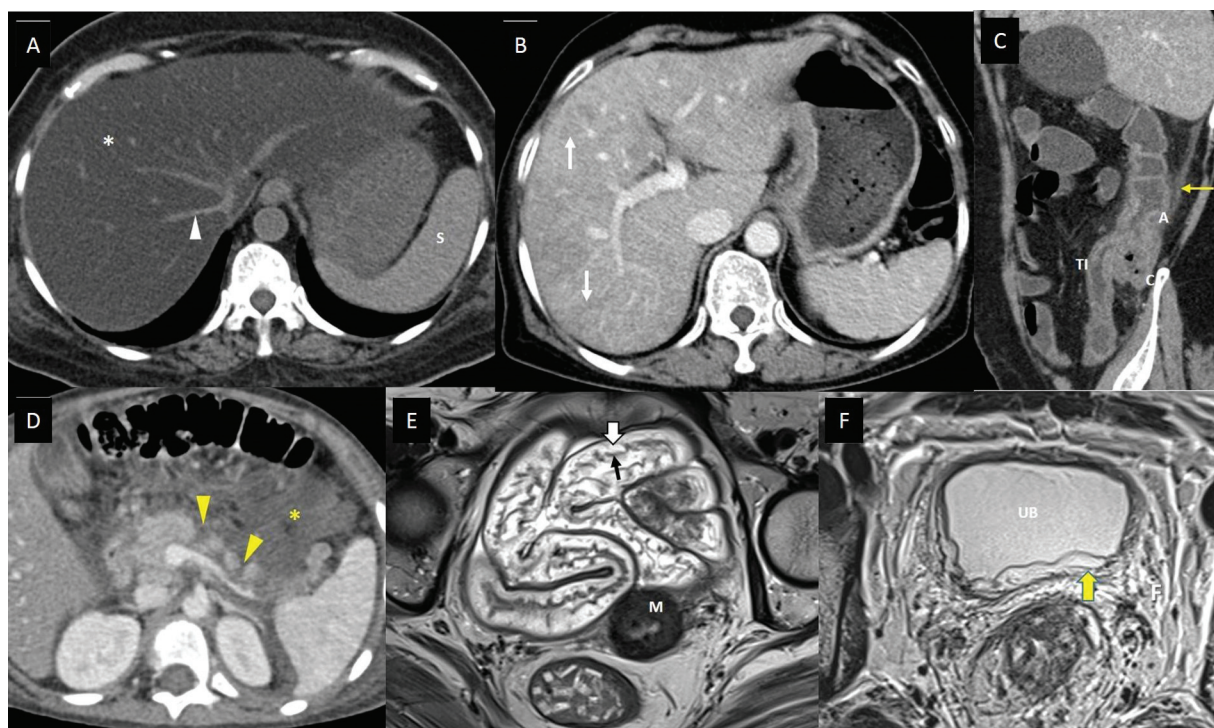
Imaging features of abdominal complications of cancer therapy. (A) A 53-year-old suffering from acute lymphoblastic leukemia, on treatment with steroids and L-asparaginase, presented with mild abdominal pain and hyperbilirubinemia. Axial noncontrast computed tomography (CT) scan shows markedly reduced density of the entire hepatic parenchyma (white asterisk), suggesting fatty liver. The vessels (white arrowhead) and spleen (S) appear hyperdense to hepatic parenchyma in this noncontrast phase of CT scan due to diffuse fatty infiltration. (B) A 61-year-old lady with metastatic carcinoma stomach, on treatment with oxaliplatin. Axial CT scan of the abdomen with intravenous (IV) contrast done after few cycles of chemotherapy shows heterogeneous enhancement of the hepatic parenchyma with linear hypodensities (white arrows), which is new compared to the baseline CT scan done 3 months back, suggesting oxaliplatin-induced sinusoidal obstruction syndrome. (C) A 48-year-old man with lung adenocarcinoma, treated with pembrolizumab and carboplatin, presented to the emergency department (ED) complaining of abdominal pain, multiple episodes of diarrhea, and vomiting 6 days after a chemotherapy cycle. Sagittal CT scan of the abdomen with IV contrast shows thickened and edematous wall of ascending colon (A), caecum (C), and terminal ileum (TI), with surrounding fat stranding (yellow arrow), and maintained mural stratification. The patient was found to be severely neutropenic, and these imaging findings along with the clinical presentation, suggested neutropenic enterocolitis/typhlitis. (D) A 6-year-old boy suffering from acute lymphoblastic leukemia, on treatment regimen containing L-asparaginase, presented to the ED with acute abdominal pain and vomiting. He was found to be hypotensive and serum amylase and lipase were raised. Axial CT scan of the abdomen with IV contrast shows nonenhancing areas within the pancreatic parenchyma indicating necrosis (yellow arrowheads), and collection in peripancreatic region containing foci of fat (yellow asterisk). The features suggest acute necrotizing pancreatitis with peripancreatic fat necrosis. (E) A 47-year-old lady receiving radiation therapy for carcinoma of the cervix uteri, underwent response assessment magnetic resonance imaging (MRI) after 20 fractions along with cisplatin. Axial T2-weighted MR image shows submucosal edema as hyperintense signals (white block arrow) deep to the hypointense mucosal layer (black arrow), and maintained mural stratification, involving pelvic small bowel loops, indicating radiation-induced enteritis. The tumor with posttreatment changes is seen involving the cervix (M). (F) A 32-year-old man with rectal adenocarcinoma, underwent a response assessment MRI after neoadjuvant chemoradiotherapy. He complained of mild lower urinary tract symptoms. Axial T2-weighted MR image shows edematous wall of urinary bladder (UB), with hyperintense signals involving the submucosa and muscularis (yellow block arrow), and surrounding edematous pelvic fat (F). The features suggested radiation-induced cystitis.
